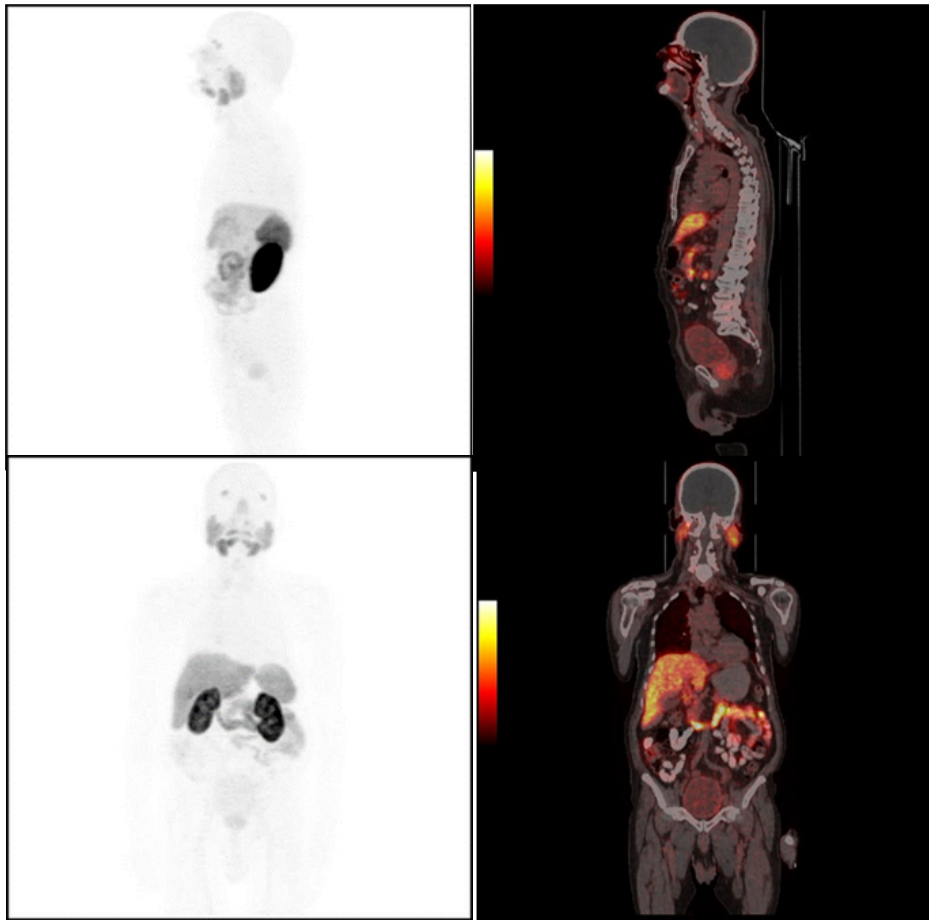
Ga-68 PSMA PET scan following 3 cycles of Lu-PSMA treatment to assess treatment efficacy.
